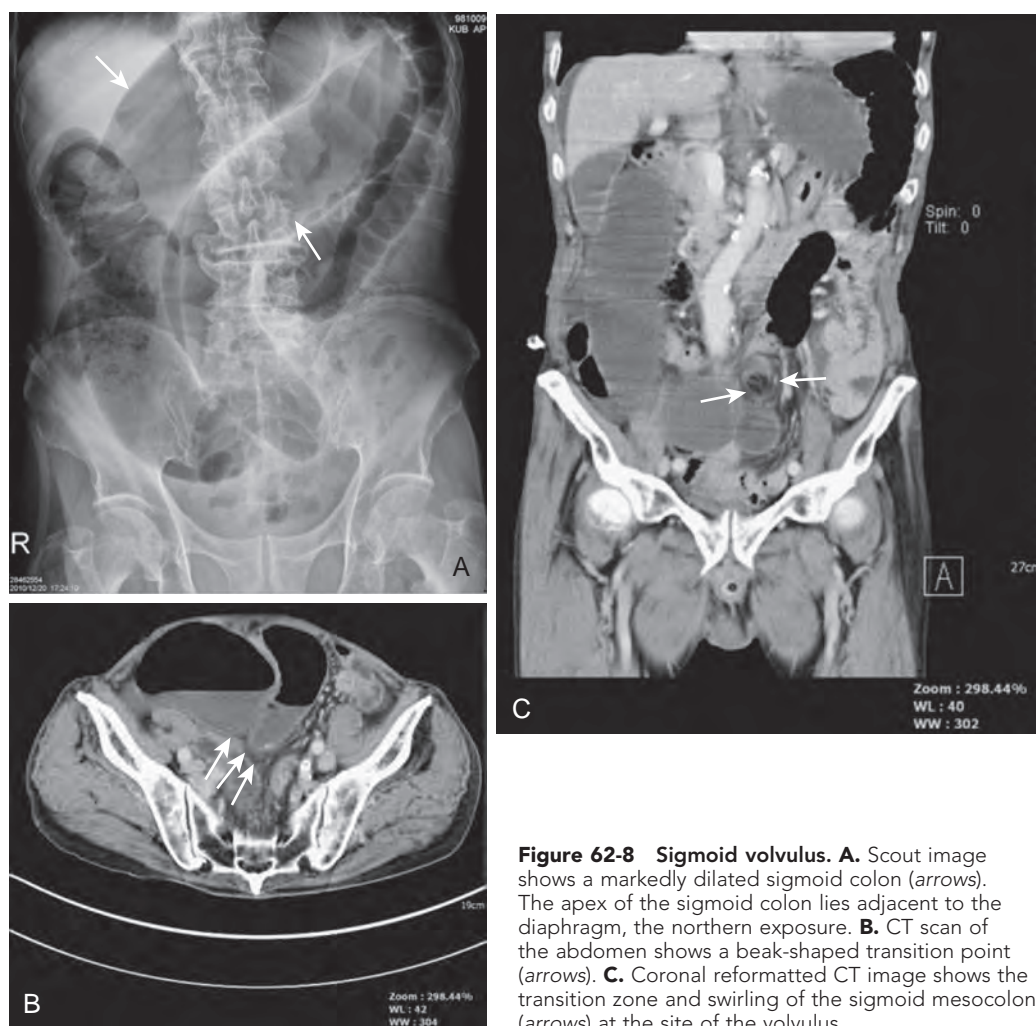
Sigmoid volvulus. A. Scout image shows a markedly dilated sigmoid colon (arrows). The apex of the sigmoid colon lies adjacent to the diaphragm, the northern exposure. B. CT scan of the abdomen shows a beak-shaped transition point (arrows). C. Coronal reformatted CT image shows the transition zone and swirling of the sigmoid mesocolon (arrows) at the site of the volvulus.
